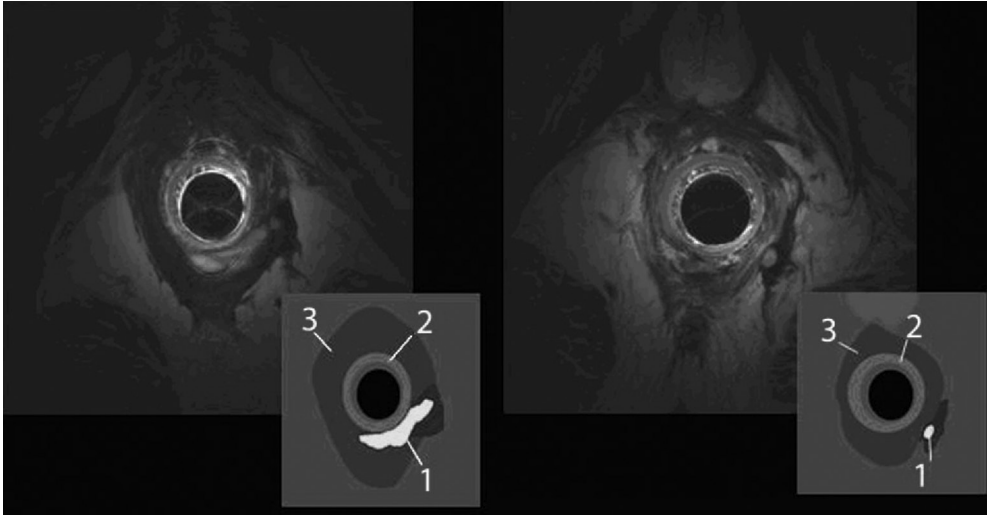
MR images of intersphincteric horseshoe fistula. 1 = fistula; 2 = internal anal sphincter; 3 = external anal sphincter.
